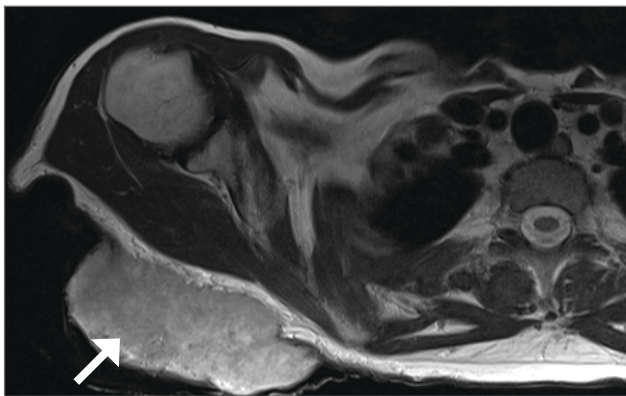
Magnetic resonance imaging of the right shoulder demonstrating a subcutaneous mass (arrow) without local extension to muscle or bone.
